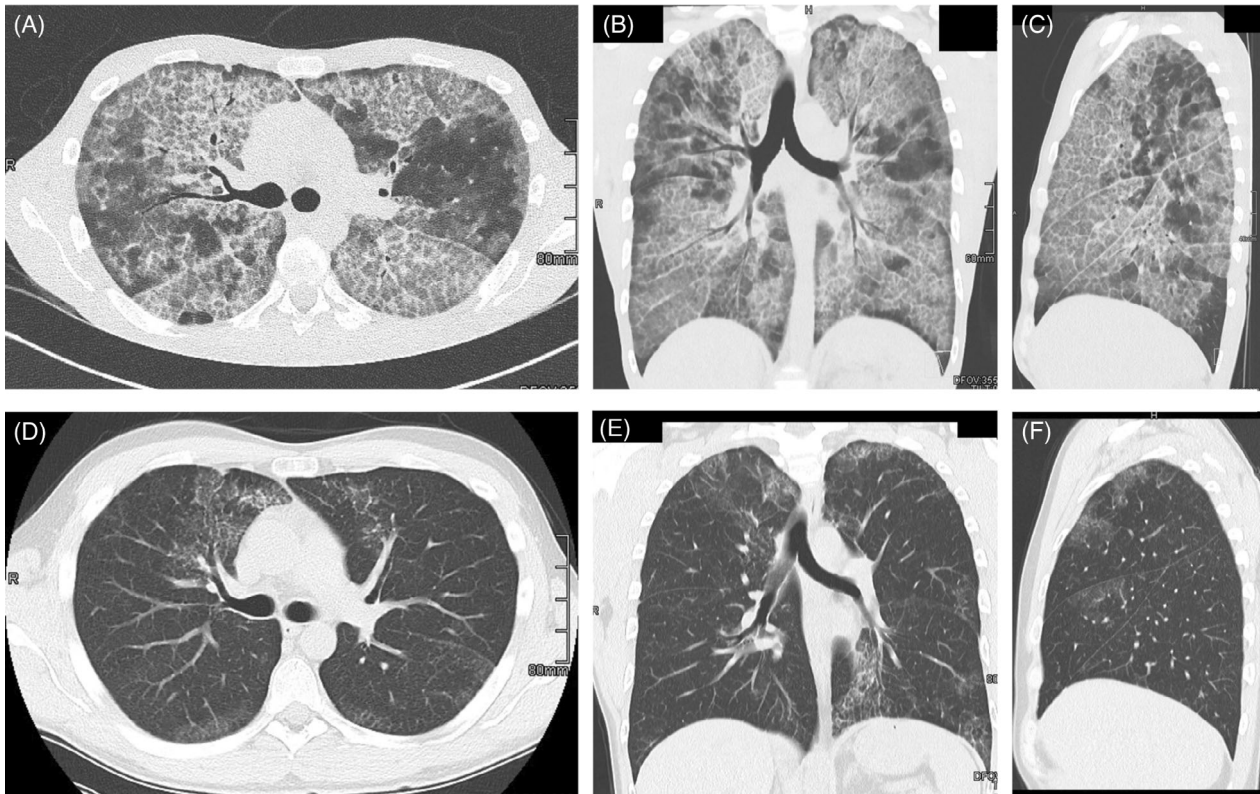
Chest computed tomography images demonstrating a 'crazy-paving' appearance of interlobular septal thickening and associated ground-glass interstitial opacities without zonal predominance at presentation (A–C) with marked improvement in magnitude and extent of abnormalities following sequential whole-lung lavage (D–F)
